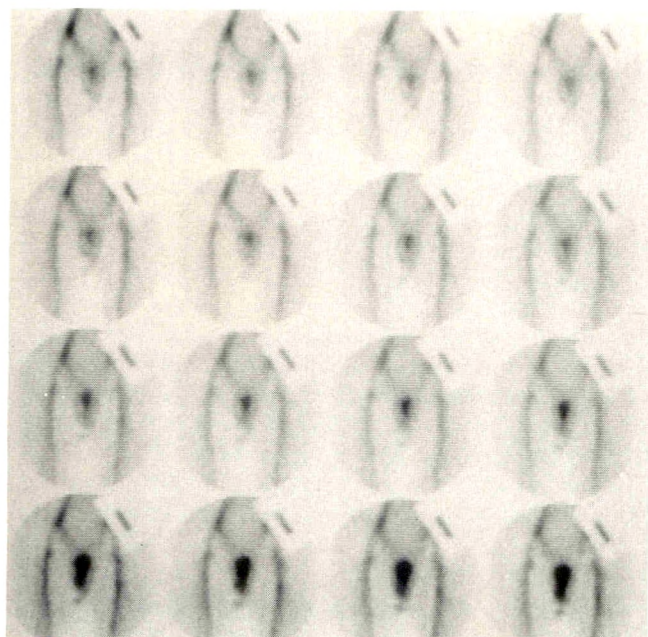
^{99m}Tc -labeled RBC scintigrams in a patient with excellent arterial inflow and moderate venous leakage. Top row shows equilibrium and infusion of papaverine. Bottom three rows show penile blood flow 1, 2, and 3 min after intracorporeal papaverine infusion. Each row represents 1 min. (Reproduced with permission from Schwartz et al. [32].)
